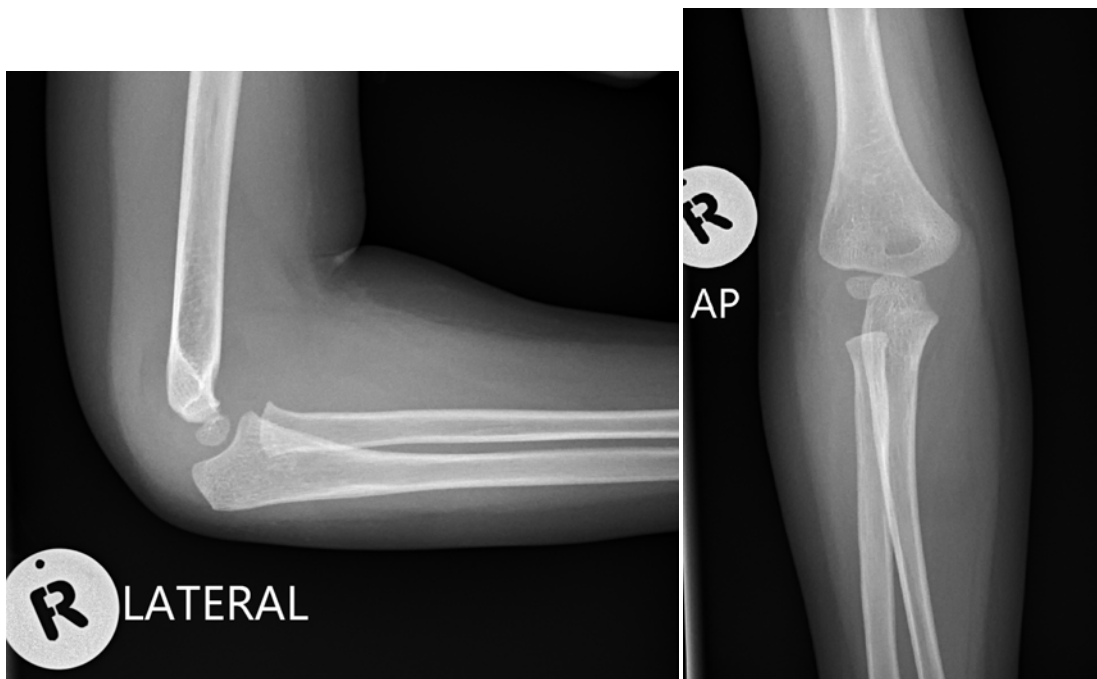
Lateral and AP radiographs of slide 20 (pre tutorial) and slide 12 (post tutorial)
